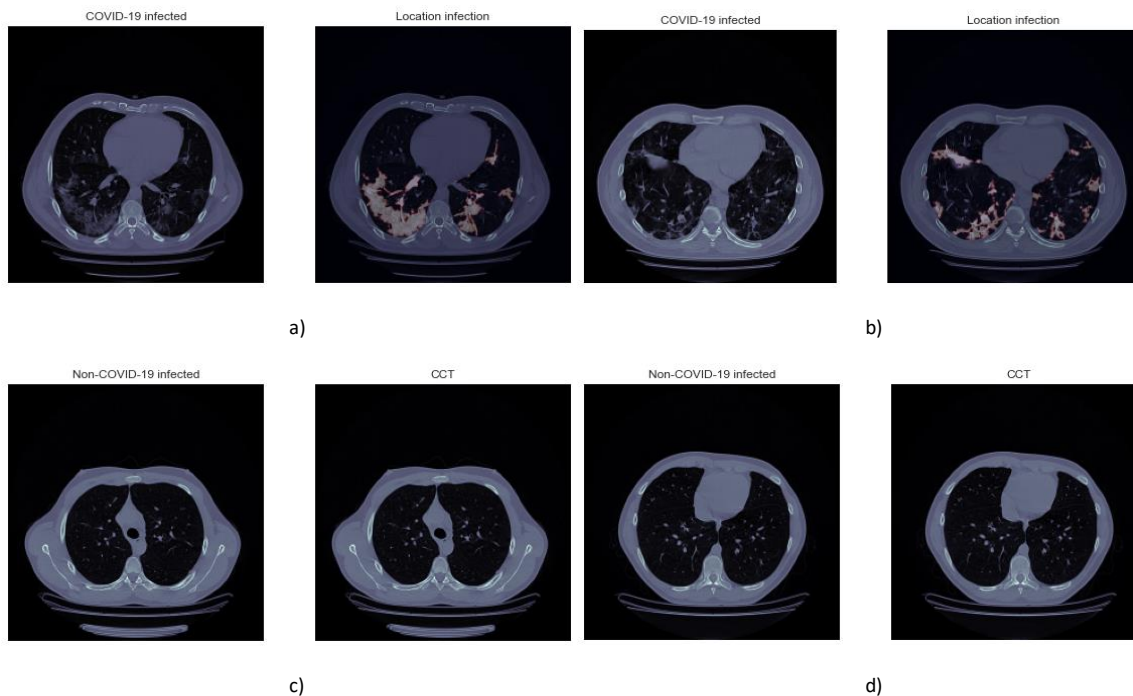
The predicted results of 4 different patients: Sections (a) and (b) correspond to two CT scans (left) and their location infection (right) of COVID-19 patients. Sections (c) and (d) correspond to two CT scans (left) and the repeated image without infect.
